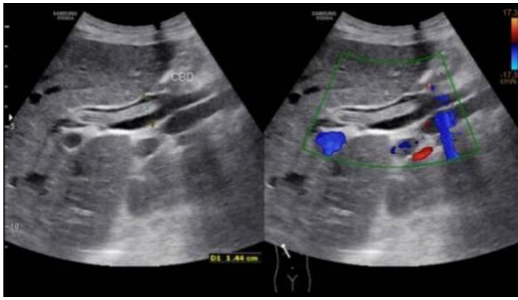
Ultrasound image from the formal ultrasound hepatobiliary system showing a dilated common bile duct with the presence of a linear echogenic tubular structure inside.
